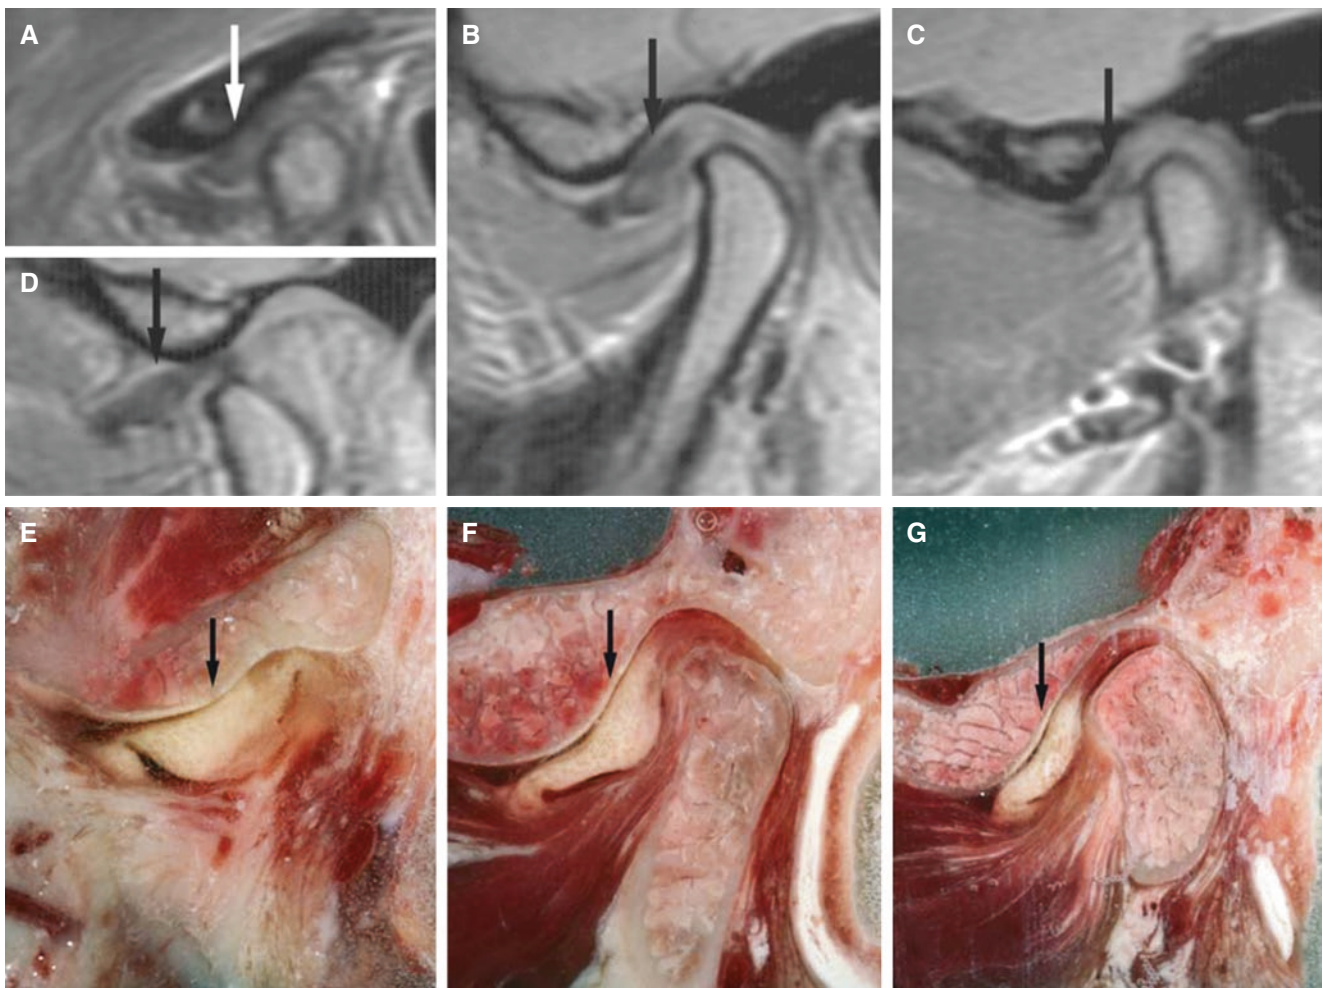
Complete anterior disc displacement (disc displaced throughout the joint) without reduction, normal bone. (A, B, C) Oblique sagittal MRI shows displaced and deformed disc (*arrow*) in lateral (A), central (B), and medial (C) section. (D) Oblique sagittal open-mouth
